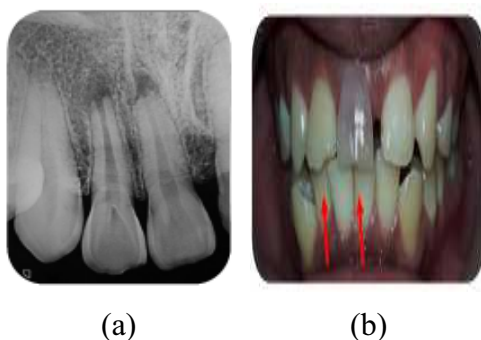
(a)Periapical radiograph tooth 11 and 21. Radiolucencies were found at the apical portion of both teeth. Open apex was also seen., (b). Clinical photograph tooth 11 and 21 from the facial aspect, no cavities found but the crown fracture was seen at the incisal edge of both teeth (red arrow).
